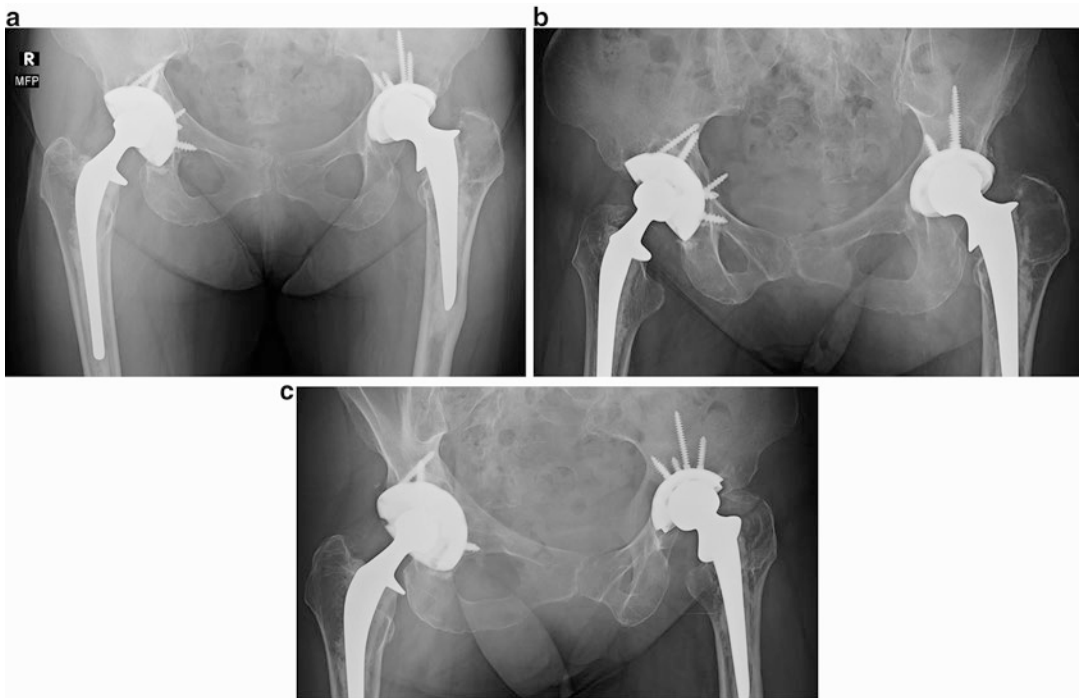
Anteroposterior pelvis (a), obturator oblique (b), and iliac oblique (c) radiographs of a patient with periacetabular osteolysis and a loose, cemented femoral component. The anteroposterior view demonstrates osteolysis
